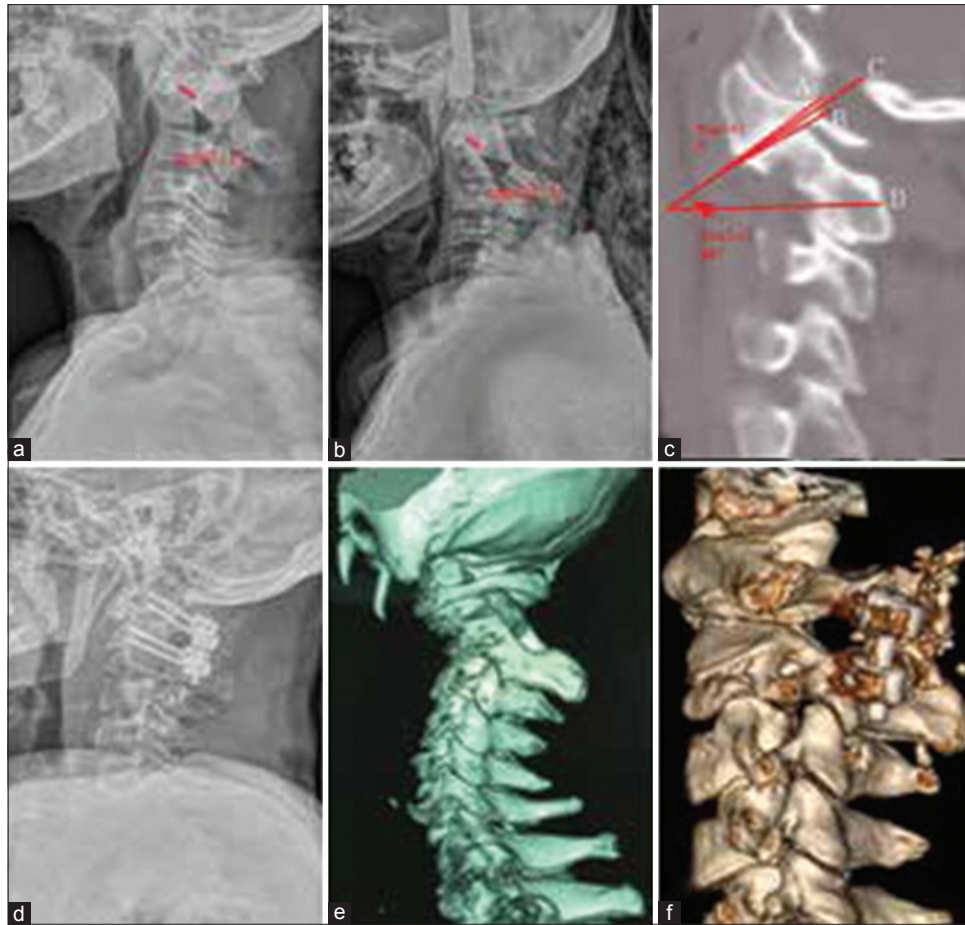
55 years old female, performed simple posterior atlantoaxial reduction and bone graft internal fixation (a and b) X-ray cervical spine lateral view showing atlas-dens interval before and after the traction was 9.32 mm and 6.14 mm, respectively; reduction index was 34.29%; (c) 3-D reconstructed image cervical spine showing obvious forward and downward atlantoaxial dislocation toward axis before the traction (d and e) CT cervical spine paracervical sagittal view showing the left and right sagittal atlantoaxial joint inclinations were 22° and 24°, respectively (f) the postoperative X-ray cervical spine lateral view showing that atlas-dens interval was significantly reduced
